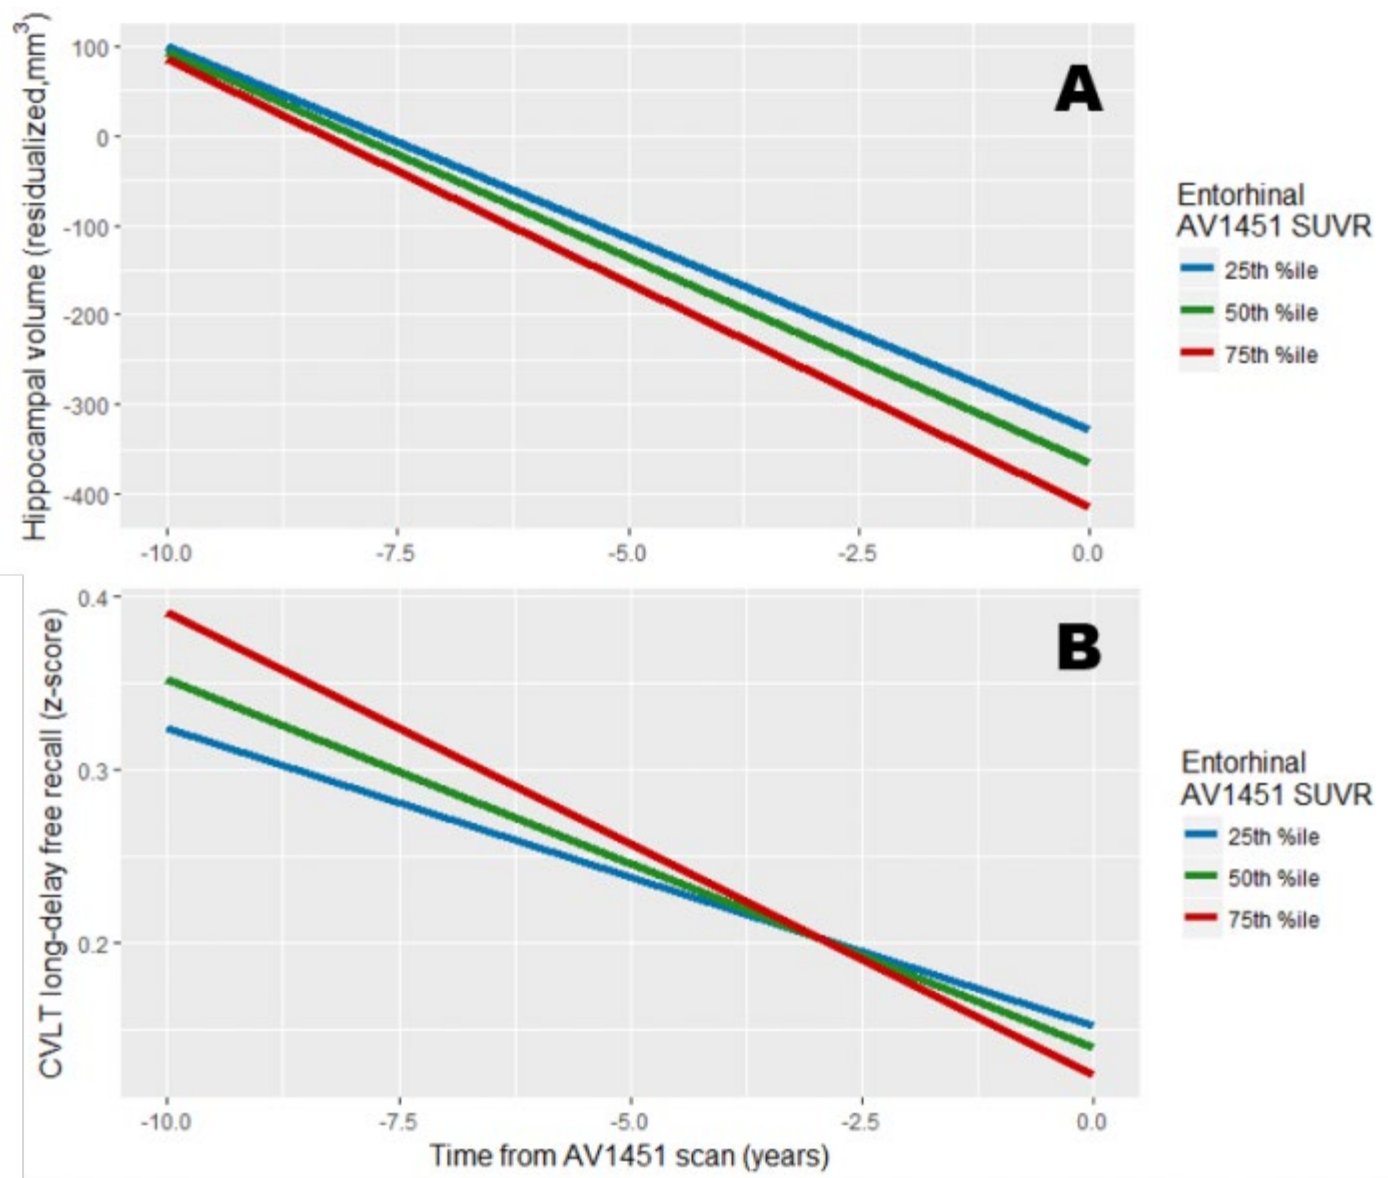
Population trajectory of (A) hippocampal volume and (B) CVLT long-delay free recall determined using linear mixed effects models with age at and time from AV1451 scan, sex, years of education, amyloid positivity, amyloid*time, entorhinal AV1451 SUVR, and entorhinal AV1451 SUVR*time as independent variables. Hippocampal volume at time of AV1451 scan, calculated as difference from expected volume at a given intracranial volume, and hippocampal volume*time are included as covariates in the association with memory. Predicted change is visualized for the population average with entorhinal cortex AV1451 SUVR in the 25th, 50th, and 75th percentile.
